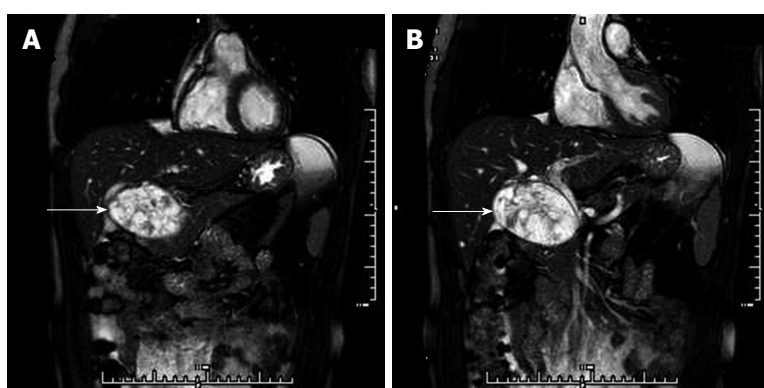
Magnetic resonance cholangiopancreatography findings. A: Magnetic resonance cholangiopancreatography (MRCP) showed that the mass (arrow) was inhomogeneous and hyperintense on T2-weighted images and probably located in the pancreatic head; B: The middle-low segment of the common bile duct was compressed.
